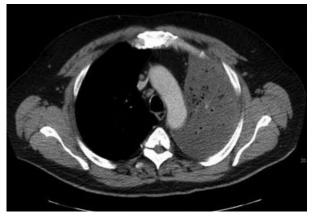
Computed tomographic scan of the chest with contrast shows necrotizing lobar pneumonia involving the left upper lobe and left lower lobe. Fine needle aspiration biopsy results revealed bronchoalveolar carcinoma.
